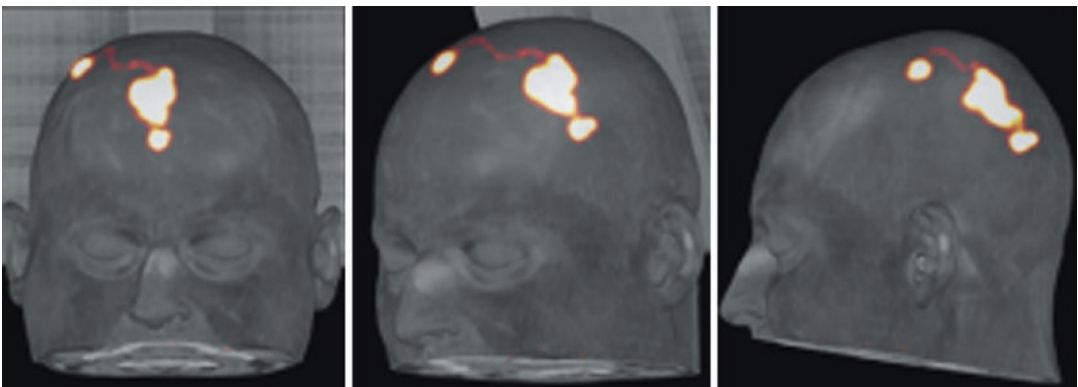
^{68}Ga -DOTA-SP PET/CT of local co-injection with therapeutic dose of ^{213}Bi -DOTA-SP to cavity of glia tumor. The picture shows small activity in capsule and catheter and major activity in cavity
